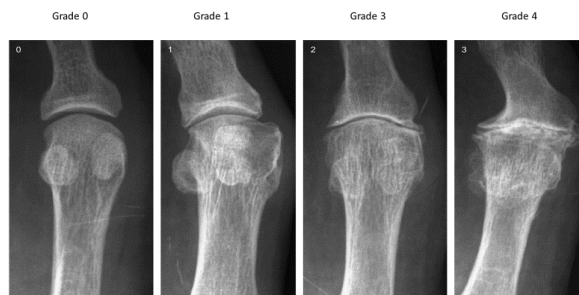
Radiographic system.
